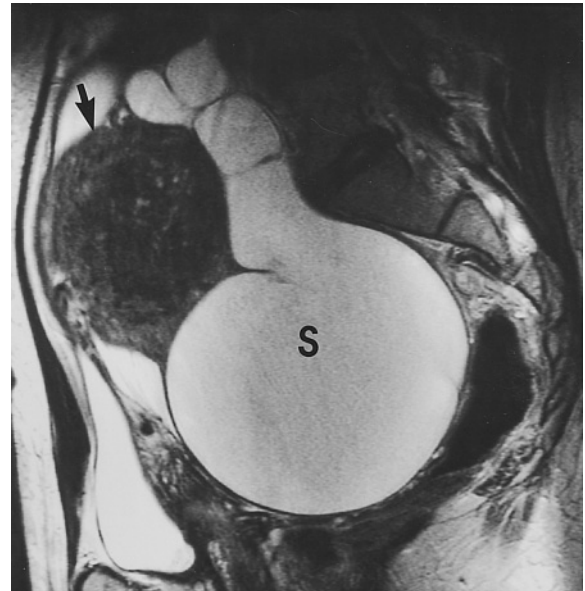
Hydrosalpinx. Sagittal 512-resolution T2-weighted ETSE image demonstrates a large hydrosalpinx (S). Adenomyosis of the uterus (arrow) is also present.
